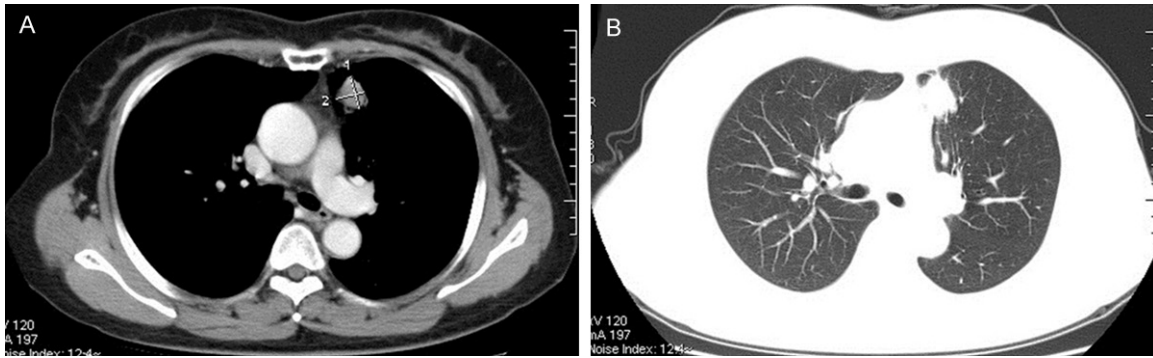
Chest computed tomography (CT) after neoadjuvant therapy. A. (mediastinal window) and B. (pulmonary window), CT scan showed that after 2 cycles of neo-adjuvant therapy, the mass was remarkably reduced.
